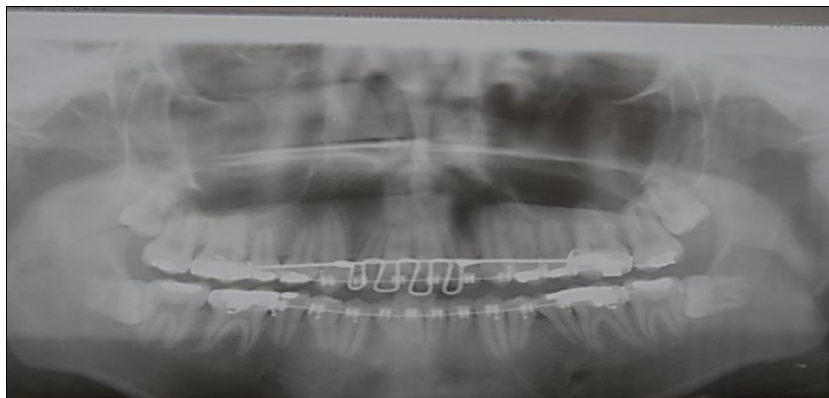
Panoramic radiograph showing retained upper and lower third molars.
